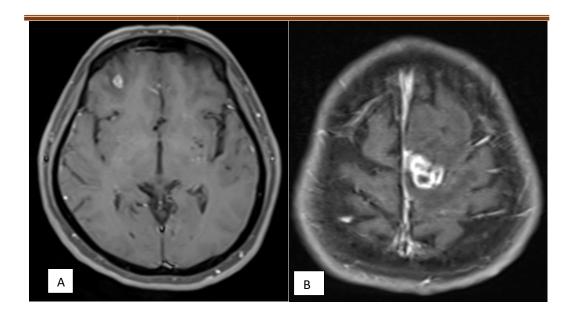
MRI images demonstrating size of lesions in our study cases
